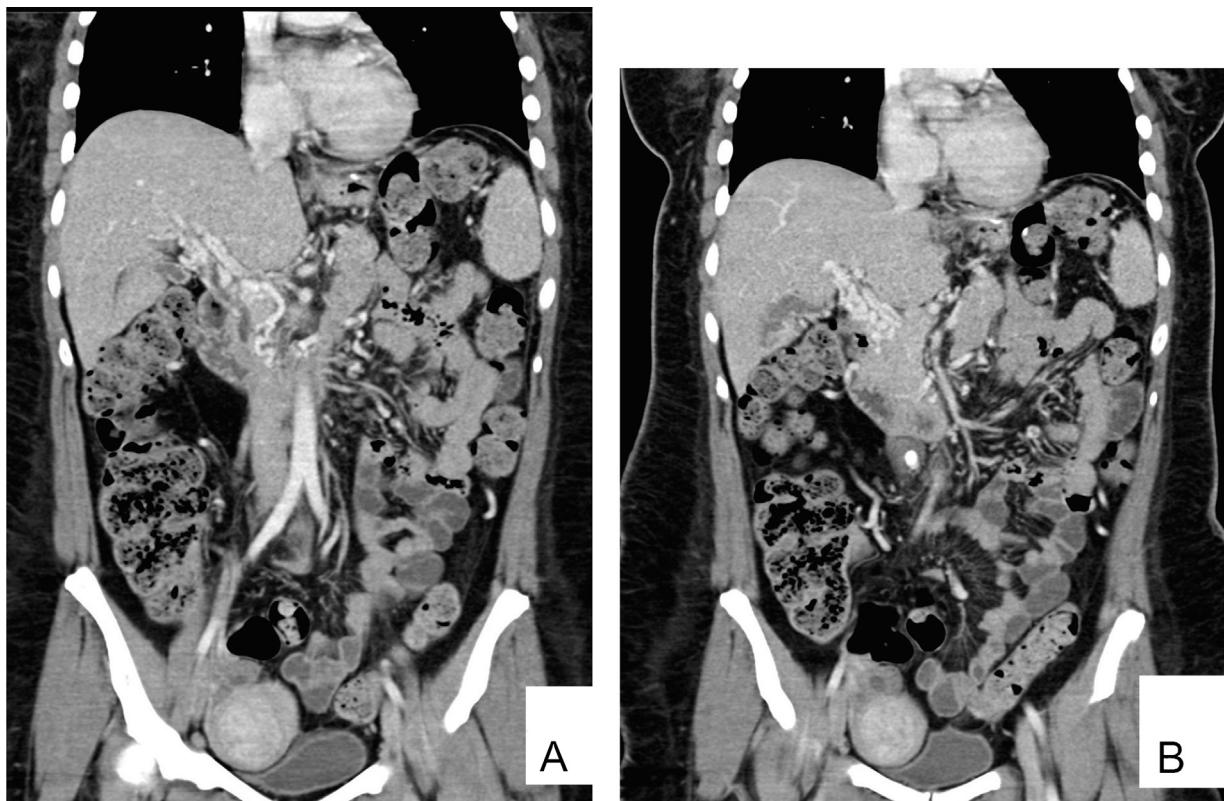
Selected coronal images of contrast enhanced CT scan of the abdomen and pelvis showing cavernous transformation of the previously thrombosed superior mesenteric and portal veins.
